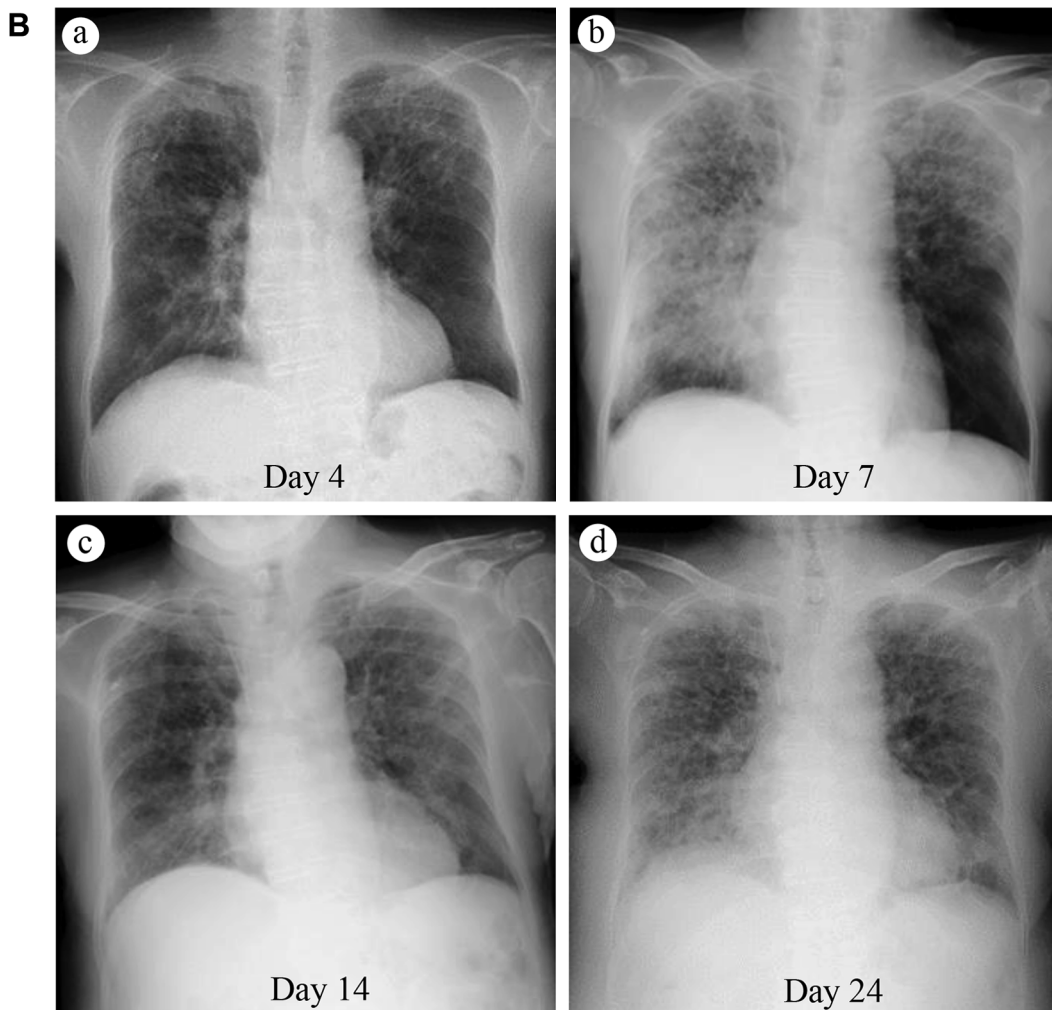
Changes over time in Chest computed tomography (CT) and chest radiography. A) (a) Chest CT on admission. (b) Chest CT on Day 16. Diffuse frosted shadows can be seen against a background of emphysematous changes. Some of the shadows are distributed in a well-defined and mottled pattern like a world map. B) (a) Chest radiography on Day 4. Mildly reduced permeability can be seen in both upper lung fields against a background of emphysematous changes. (b) Chest radiography on Day 7. Consolidation consistent with decreased permeability is visible throughout the right lung field, in addition to increased shadowing in the left upper lung field. (c) Chest radiography on Day 14. Compared to Day 7, the radiograph shows an improvement in the right lung field and left upper lung field, but increased shadowing can be seen in the left lower lung field. (d) Chest X-rays on Day 24. Diffuse increased shadows throughout both lung fields are visible.
